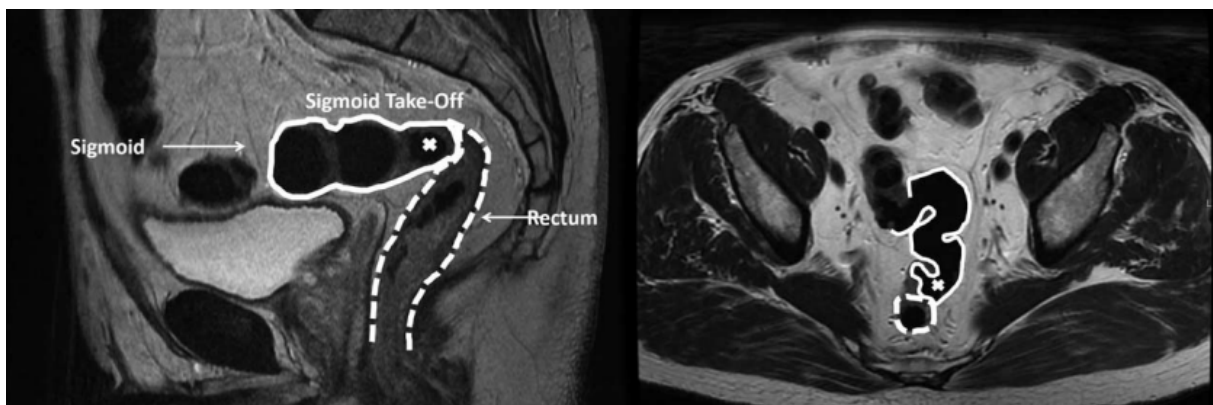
Tumor is defined as rectal cancer, if the lower border of the tumor is below the level of the sigmoid take-off, as can be seen on MRI
